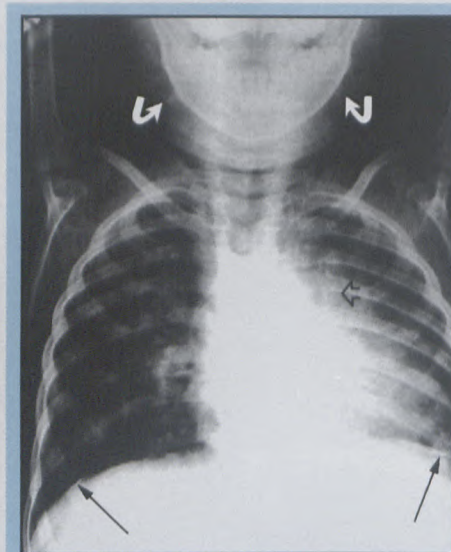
Note linear diaphragmatic pleural calcification (arrows) on chest radiograph 9 months after commencement of therapy. Also note calcified mediastinal (open arrow) and cervical (curved arrows) lymphadenopathy.
